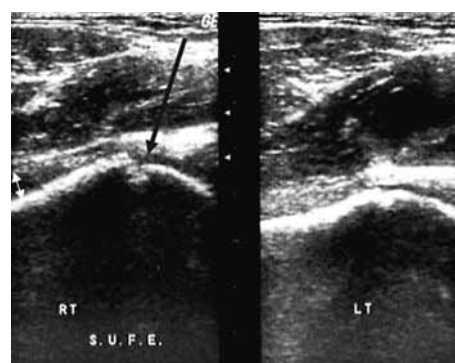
13-year-old boy who presented with right hip pain. Ultrasound scan of the right (RT) hip revealed a step at the physis-head interface (black arrow) suggestive of SUFE and a small joint effusion (white double arrow). Sonography of the left hip was normal.
